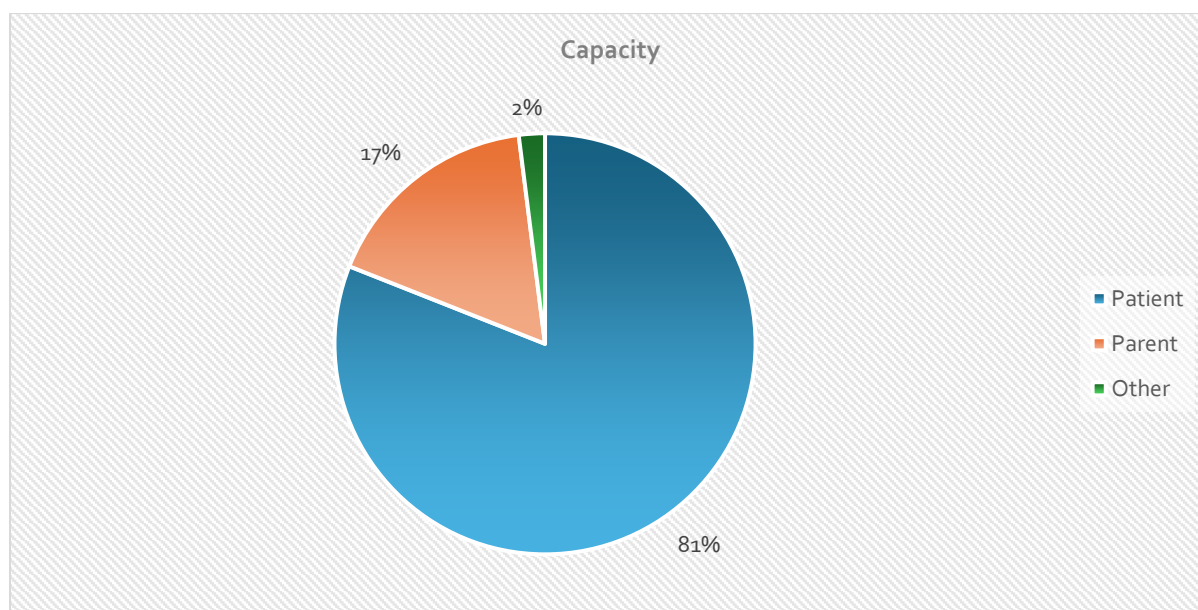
TIF MRI patient survey: respondents' capacity
